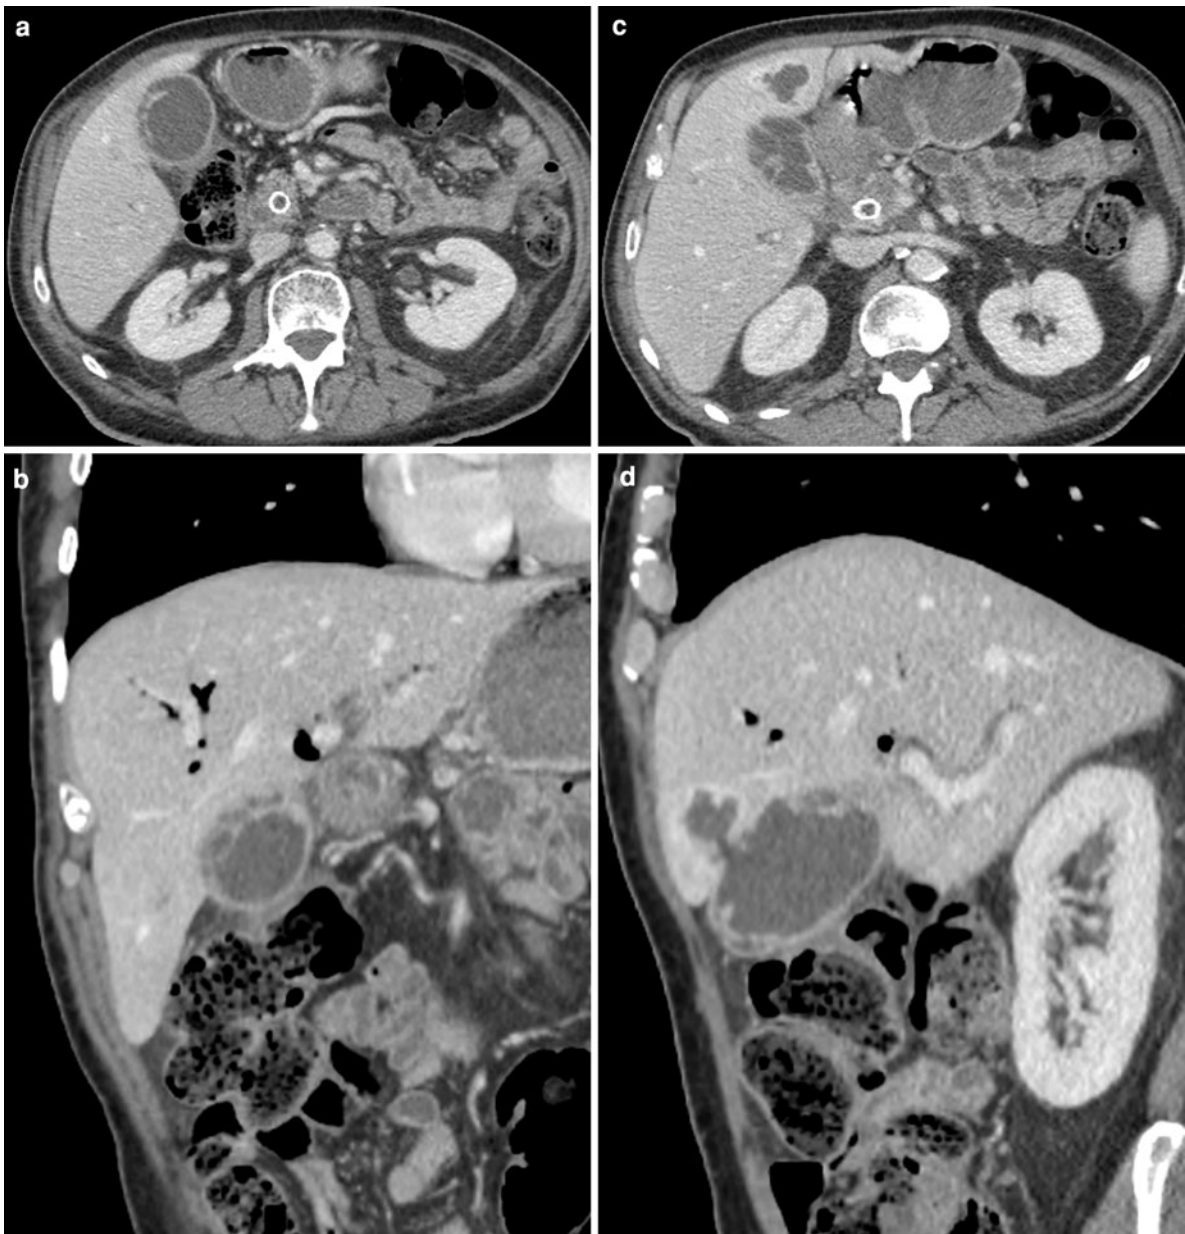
A 72-year-old man with cancer of the pancreas treated with chemotherapy and metallic stenting of the common bile duct, experiencing fever and tenderness of the right upper quadrant. Postcontrast CT shows the pancreatic tumor and the stent, and a gallbladder with thickened wall and mucosal
